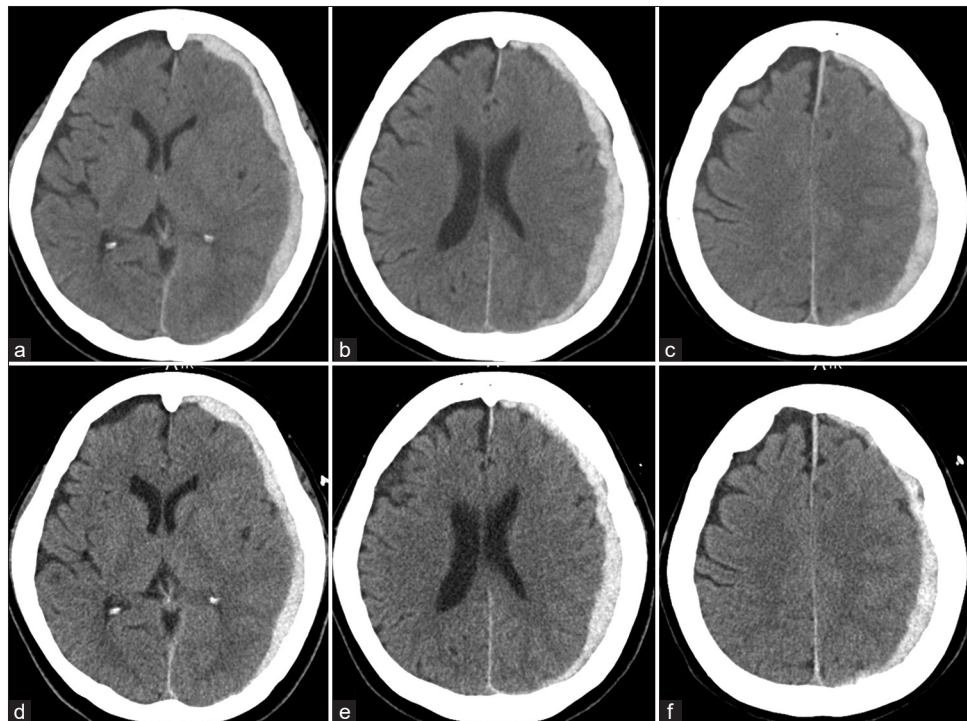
Axial computed tomography scans performed on the day of presentation (a-c) and the next day (d-f) showing a subtly compressive, the left subdural hematoma apparently in acute phase that underwent slight regression in 1 day.
